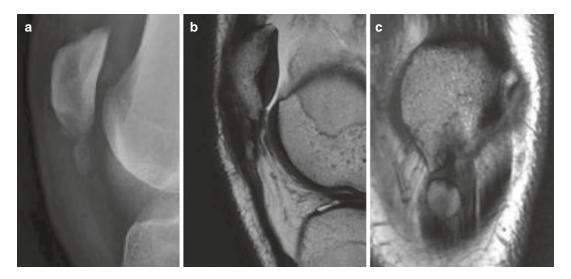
(a) Lateral X-ray (b) Sagittal MRI (c) Coronal MRI showing enthesophyte at inferior pole of patella
